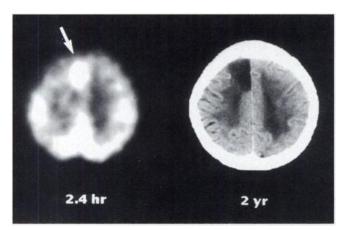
A 76-yr-old woman with sudden onset of left hemiparesis and dysarthria. Technetium-99m-HMPAO SPECT CBF image obtained 2.4 hr after the onset (left) and follow-up CT image obtained 2 yr after onset (right) show good correspondence between the hyperperfused area (arrow) and necrotic tissue in the chronic stage of infarction. The SPECT CBF image was registered and resliced after matching to follow-up CT.
